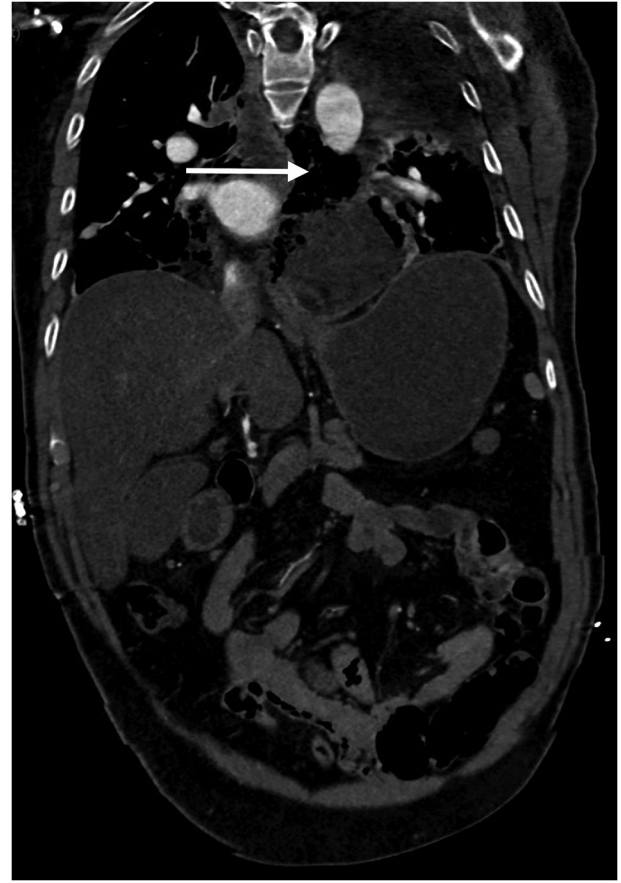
Contrast-enhanced computed tomography of the chest demonstrating high-density soft tissue surrounding the lower esophagus in the posterior mediastinum (arrow), suggestive of esophageal rupture with mediastinal contamination.
